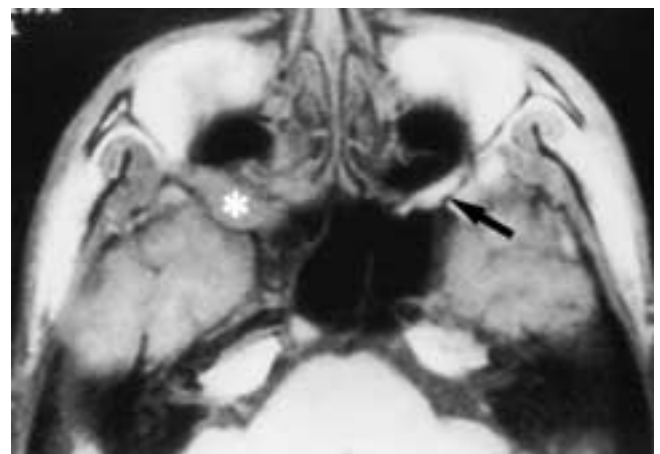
Axial noncontrast T1-weighted MR image shows enlargement of the right pterygopalatine fossa (*). Compare this to the normal fat-filled pterygopalatine fossa on the contralateral uninvolved side (arrow). (From Chong VFH, Fan YF, Mukherji SK. Carcinoma of the nasopharynx. *Semin Comput Tomogr Ultrasound MRI* 1998;19:449-462.)
